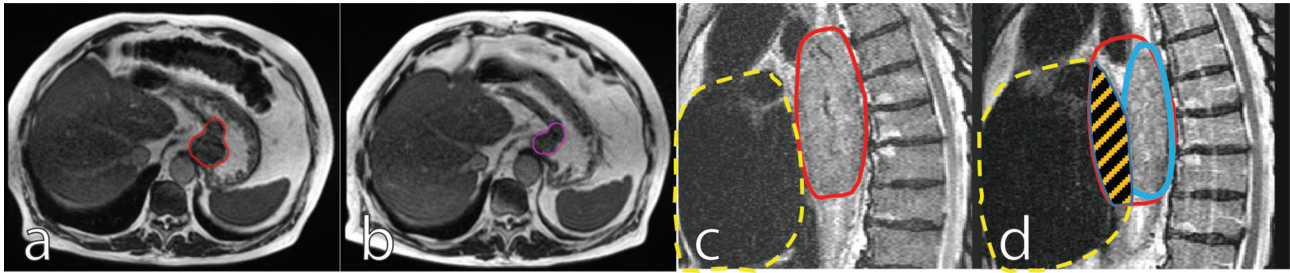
Mid treatment gastroesophageal adenocarcinoma tumor regression: Images are inhale breath hold 0.35T True Fast Imaging with Steady-State Free Precession (TRUF) at baseline [(A), red outline] and on fraction 10 of chemoradiation therapy [(B), purple outline]. Sagittal views of thoracic squamous cell carcinoma tumor regression depicted 1.5T T2-weighted navigation triggered imaging at baseline [(C), red outline] and on fraction 19 of chemoradiation therapy [(D), blue outline]. In (C, D), the dashed yellow shows the heart contour and the striped orange area shows regression from the overlap of the original tumor volume and the heart volume.
